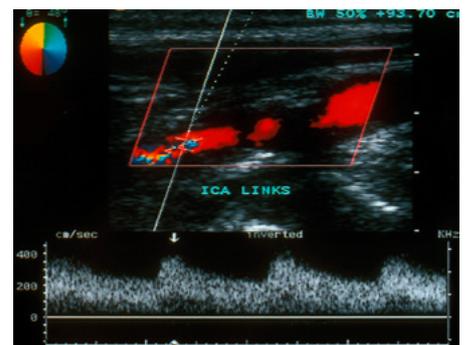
Sonography and intraoperative view of a symptomatic carotid stenosis
